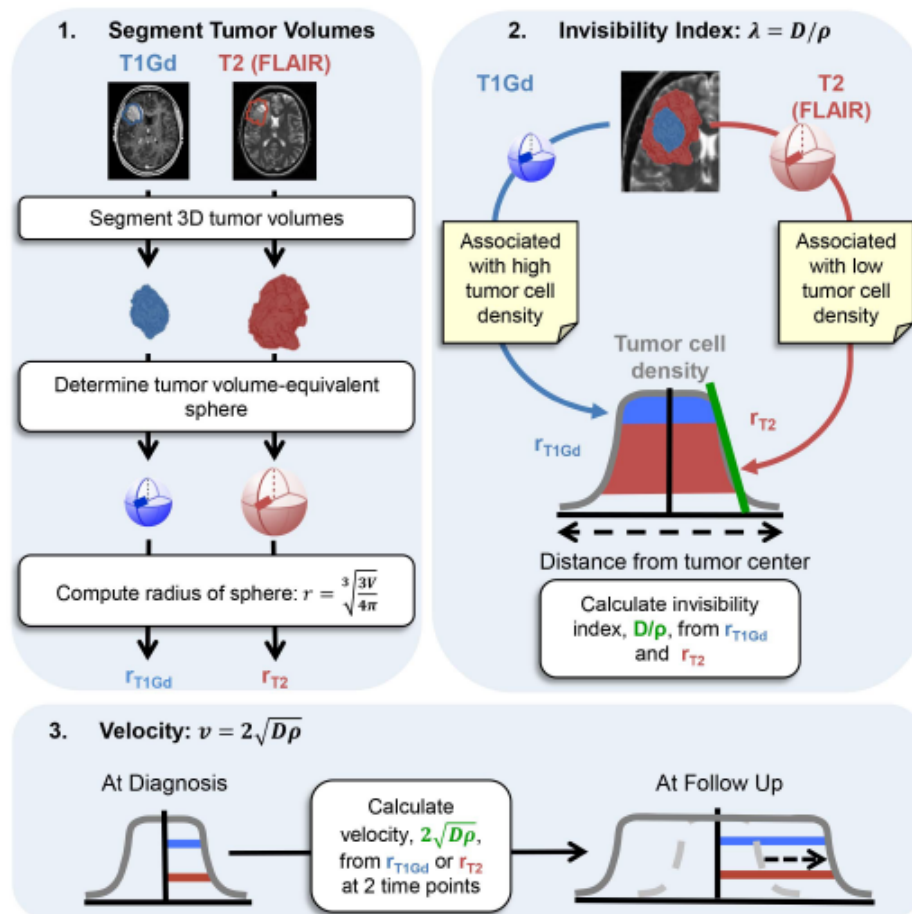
Calculation of diffusion coefficient and net proliferation rate from patient specific MRI scan [14].
